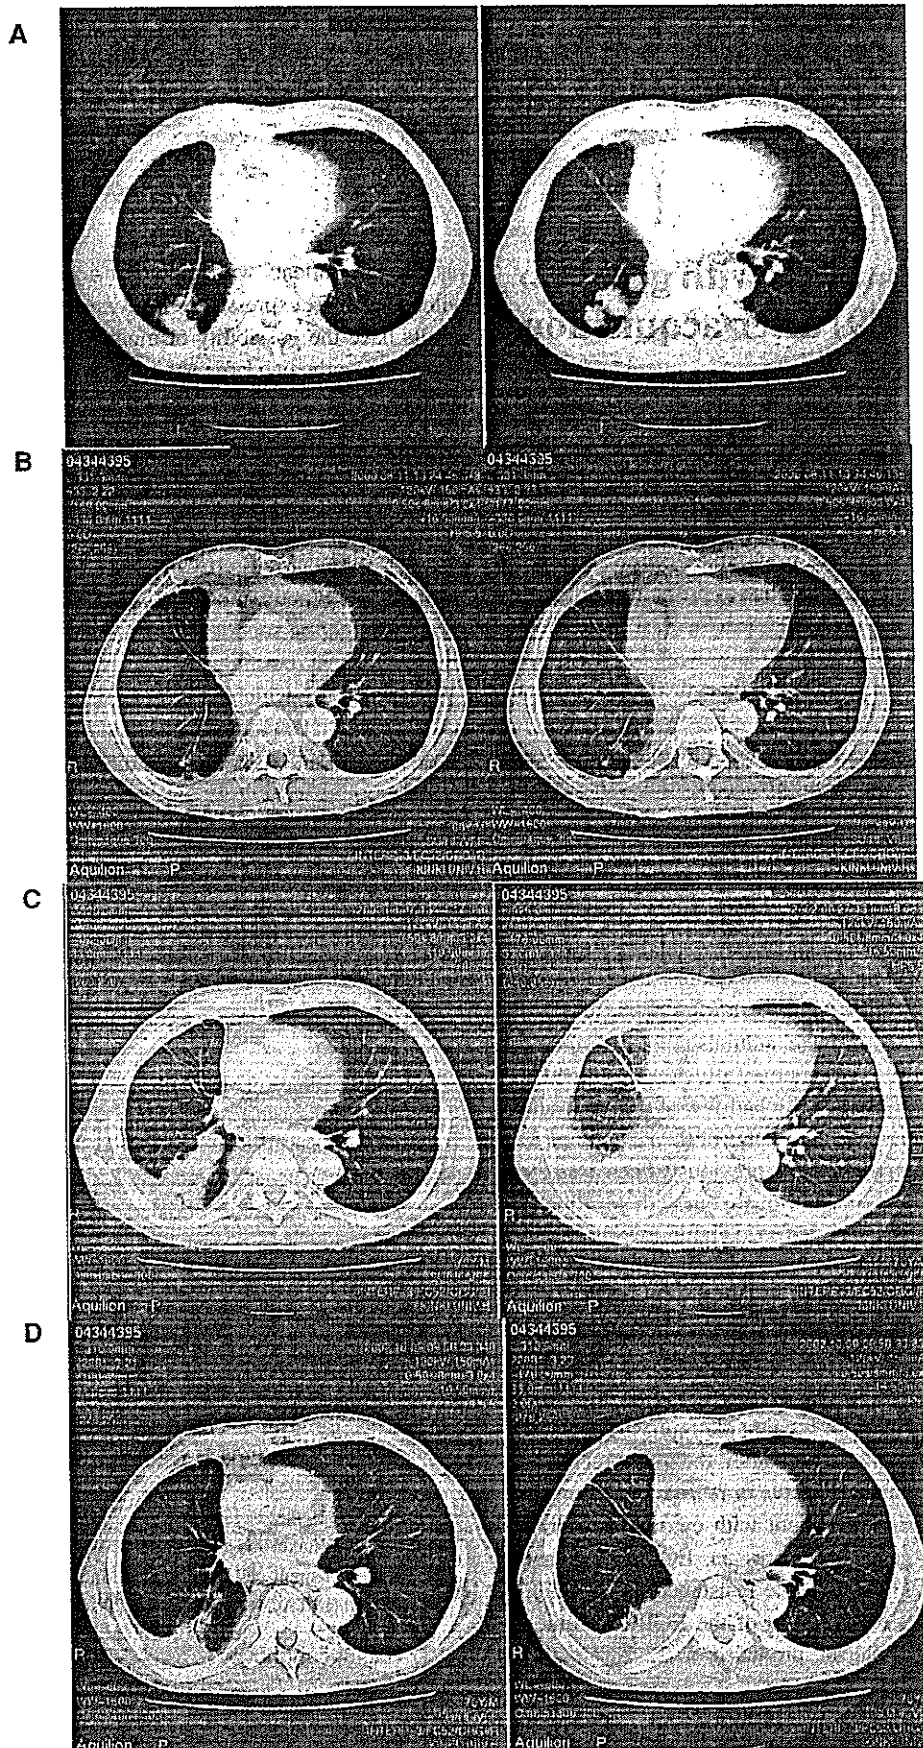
A 70-year-old man with adenocarcinoma of the lung. CT scan before treatment of gefitinib (A), after initiation of treatment (B), before re-treatment (C) and after initiation of re-treatment (D).
